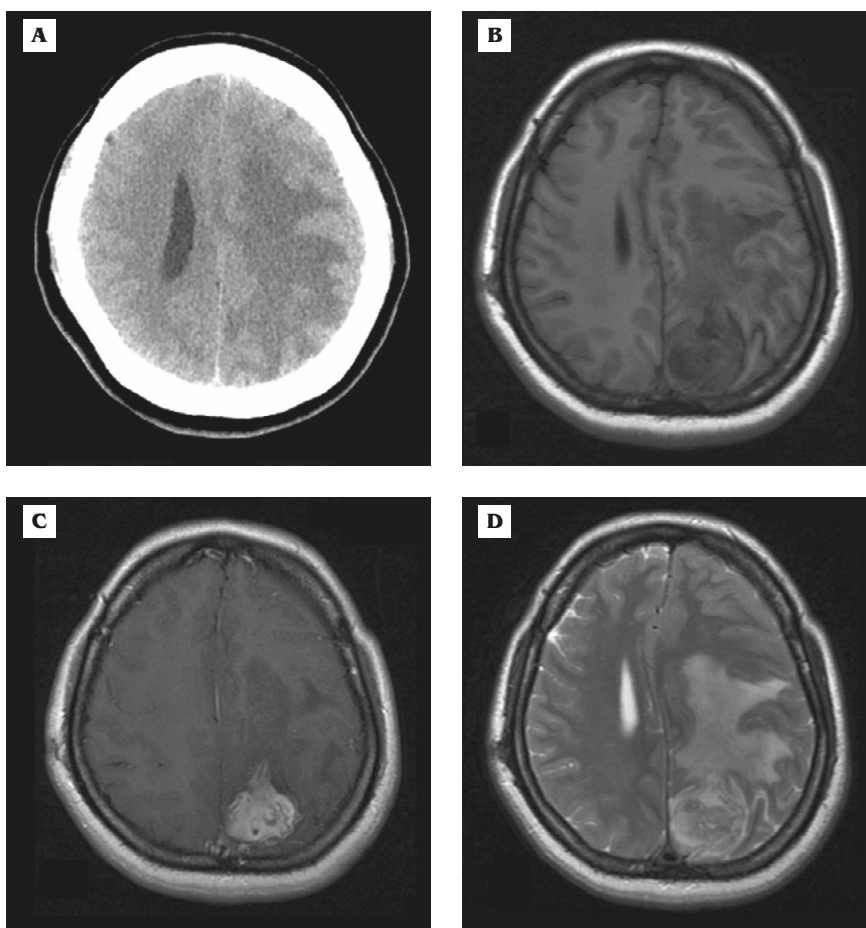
Brain imaging of a 47-year-old woman with a history of headache presenting in the ER. (A) An extensive area of white matter hypoattenuation is seen on unenhanced computed tomography with mass effect. (B) A mixed intensity lesion and hypointensity in the white matter are seen on T1-weighted fluid-attenuated inversion recovery (FLAIR) magnetic resonance imaging (MRI) and mass effect is noted. (C) T1-weighted FLAIR postcontrast MRI shows a heterogeneous enhanced mass in the left parietal lobe. (D) T2-weighted MRI of the same section as (B) shows a hyperintense area in the left parietal lobe with a heterogeneous mass near the occipital cortex.
